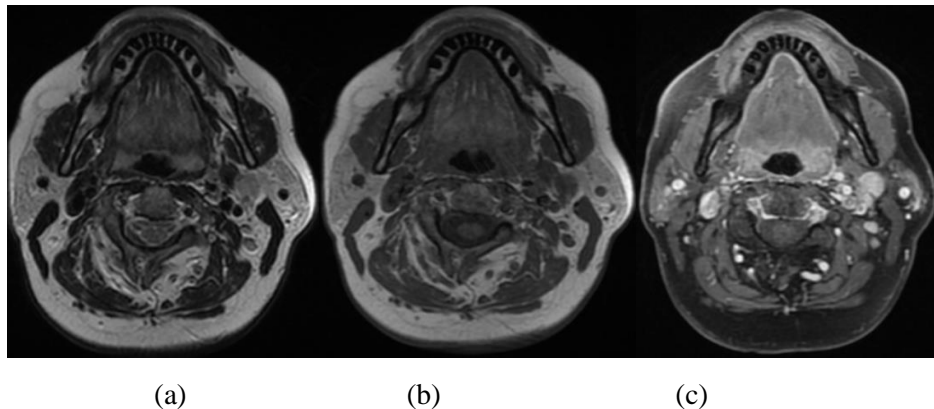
MR images with different contrast mechanisms (a) T2 (b) T1 and (c) T1+Gd. T1+Gd are often used to identify tumour as tumorous tissues on T1+Gd MRI slice appear bright (higher grey level) compared to healthy tissues and thus can be easily noticed.
